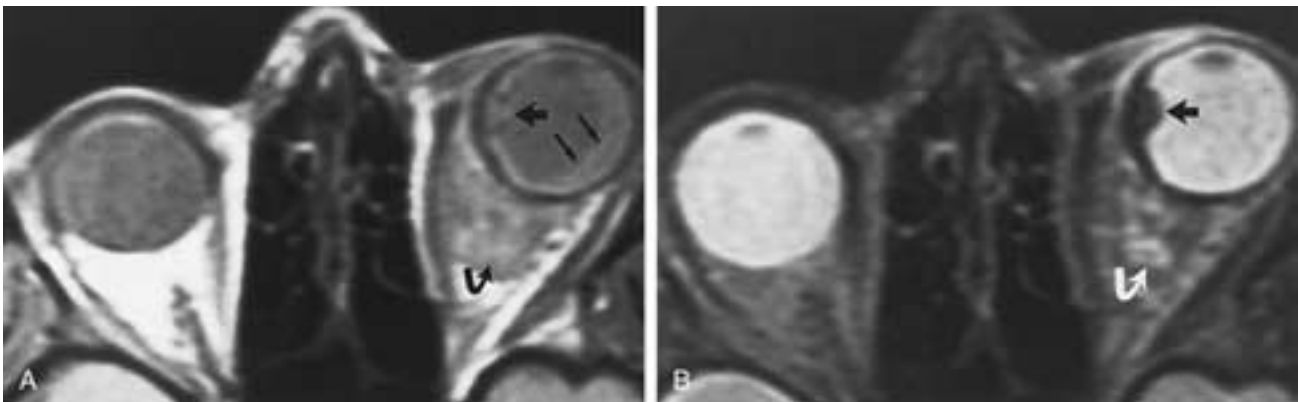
Uveal melanoma with massive retrobulbar extension. A, Axial PW and B, T2-weighted MR images. Scans show uveal melanoma (*large arrow*), subretinal fluid (*small arrows*), and massive extraocular tumor extension (*curved arrow*).
